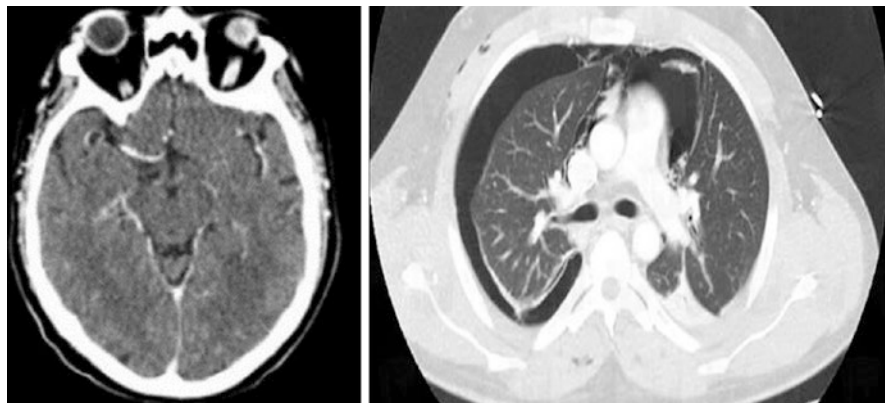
Computed tomography (CT) scan of the brain (left panel) and the thorax (right panel), in a 38-year-old woman who presented suddenly with headaches, bilateral blindness, and chest pain 4 h after coelioscopy for ovarian resection. CT scan showed multiple air-density areas in both cerebral hemispheres (left panel) and a right pneumothorax and air in the intrathoracic vessels (right panel)
